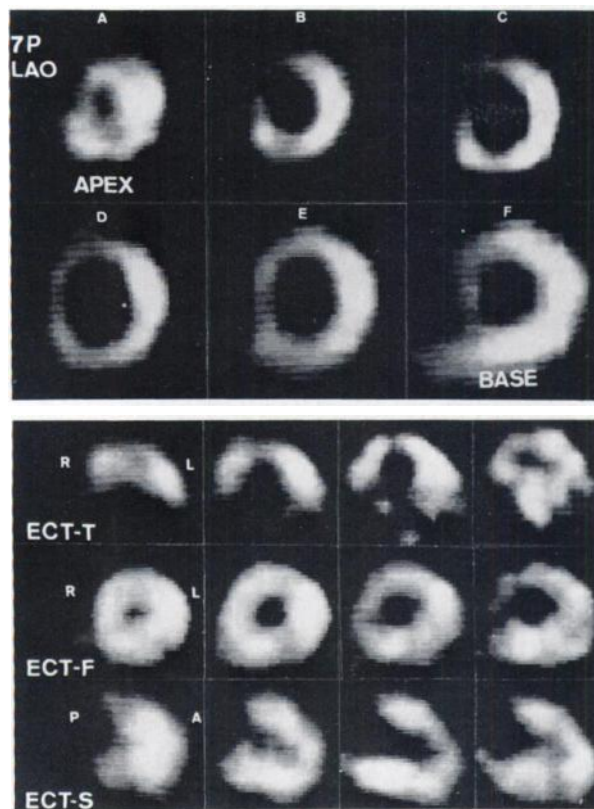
7P and SPECT Images in patient with no evidence of myocardial infarction. Perfusion defect in anteroapical wall is falsely suggested by 7P tomography; this results from anterior propagation of left-ventricular outflow tract.
